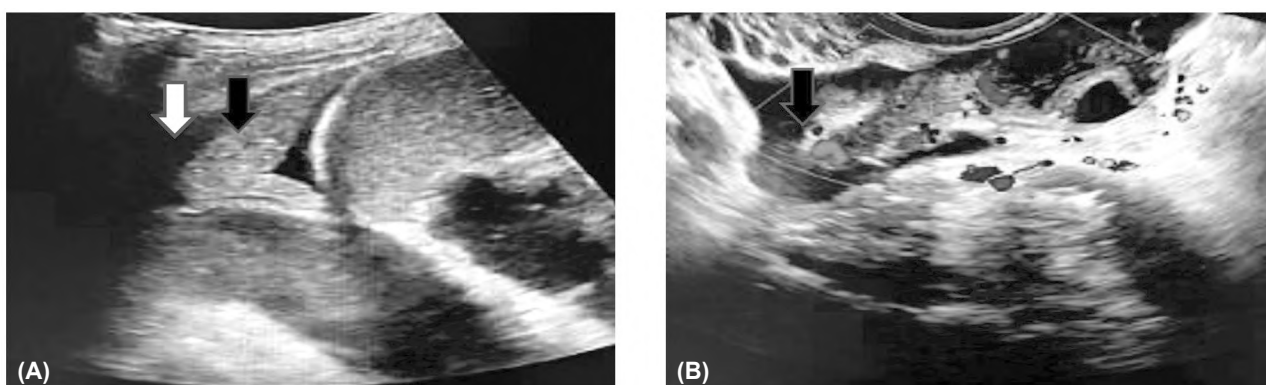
Pneumonia in a 24-year-old female with fever, cough and dyspnea. (A): Ultrasound showing consolidation isoechoic to the liver (black arrow), with pleural effusion (white arrow). (B): Prominent parenchymal vascularity (Black arrow).
